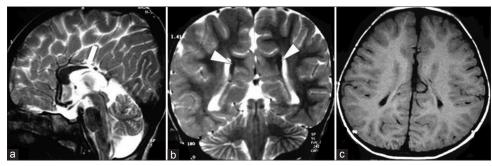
Cranial MRI, (a) Sagittal T2W MRI showing absent posterior body and splenium of corpus callosum (arrow), cingulate gyrus and the medial hemispheric sulci reaching upto the 3rd ventricular surface. (b) Coronal T2WI showing Probst bundle indenting medial aspect of the body of lateral ventricles. (c) Axial T1WI showing parallel orientation of ventricles
